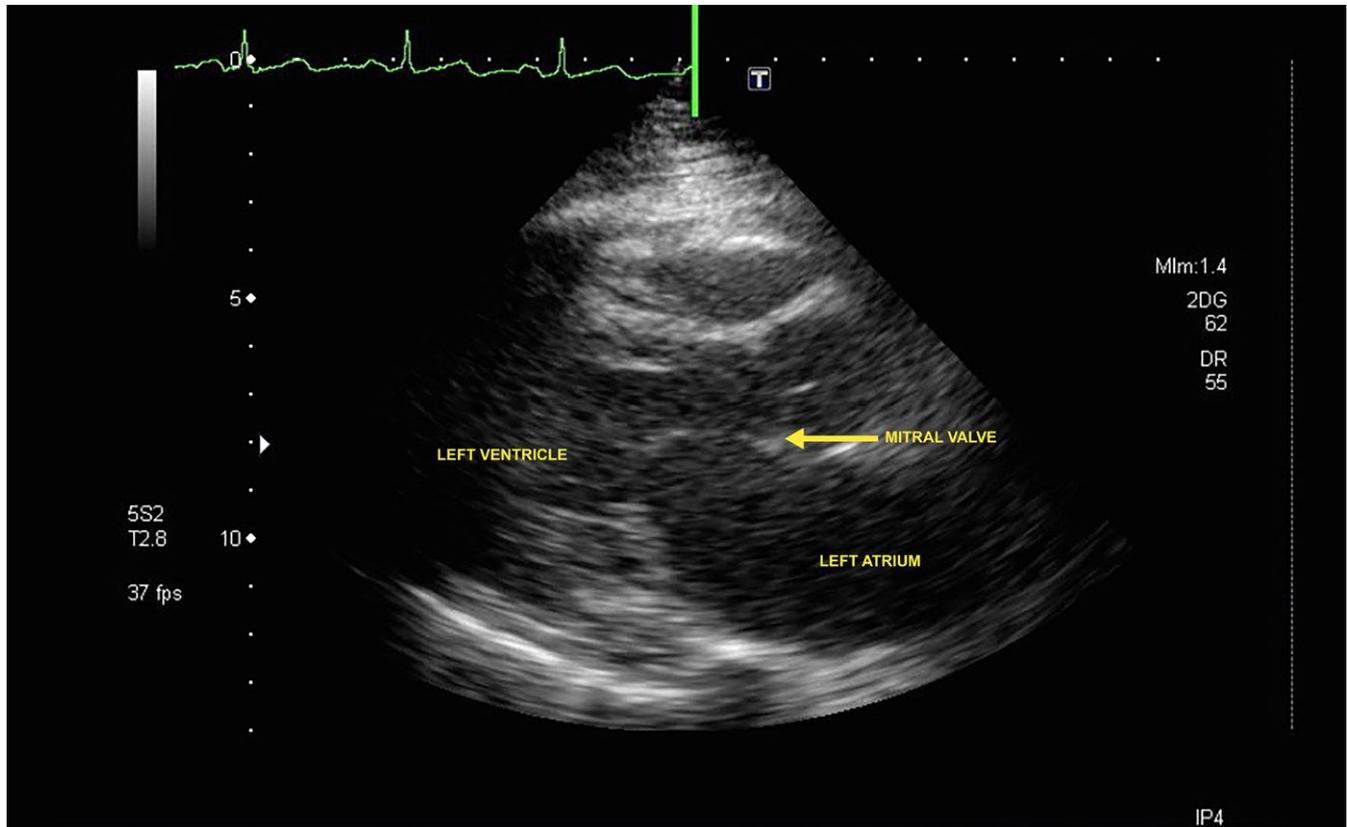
Parasternal long-axis view (transthoracic echocardiography) showing restricted mitral valve opening with diastolic doming
